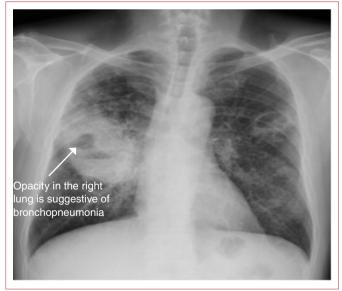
Chest radiograph (X-ray) of Case 2 showing inhomogeneous opacity in the right lung.
